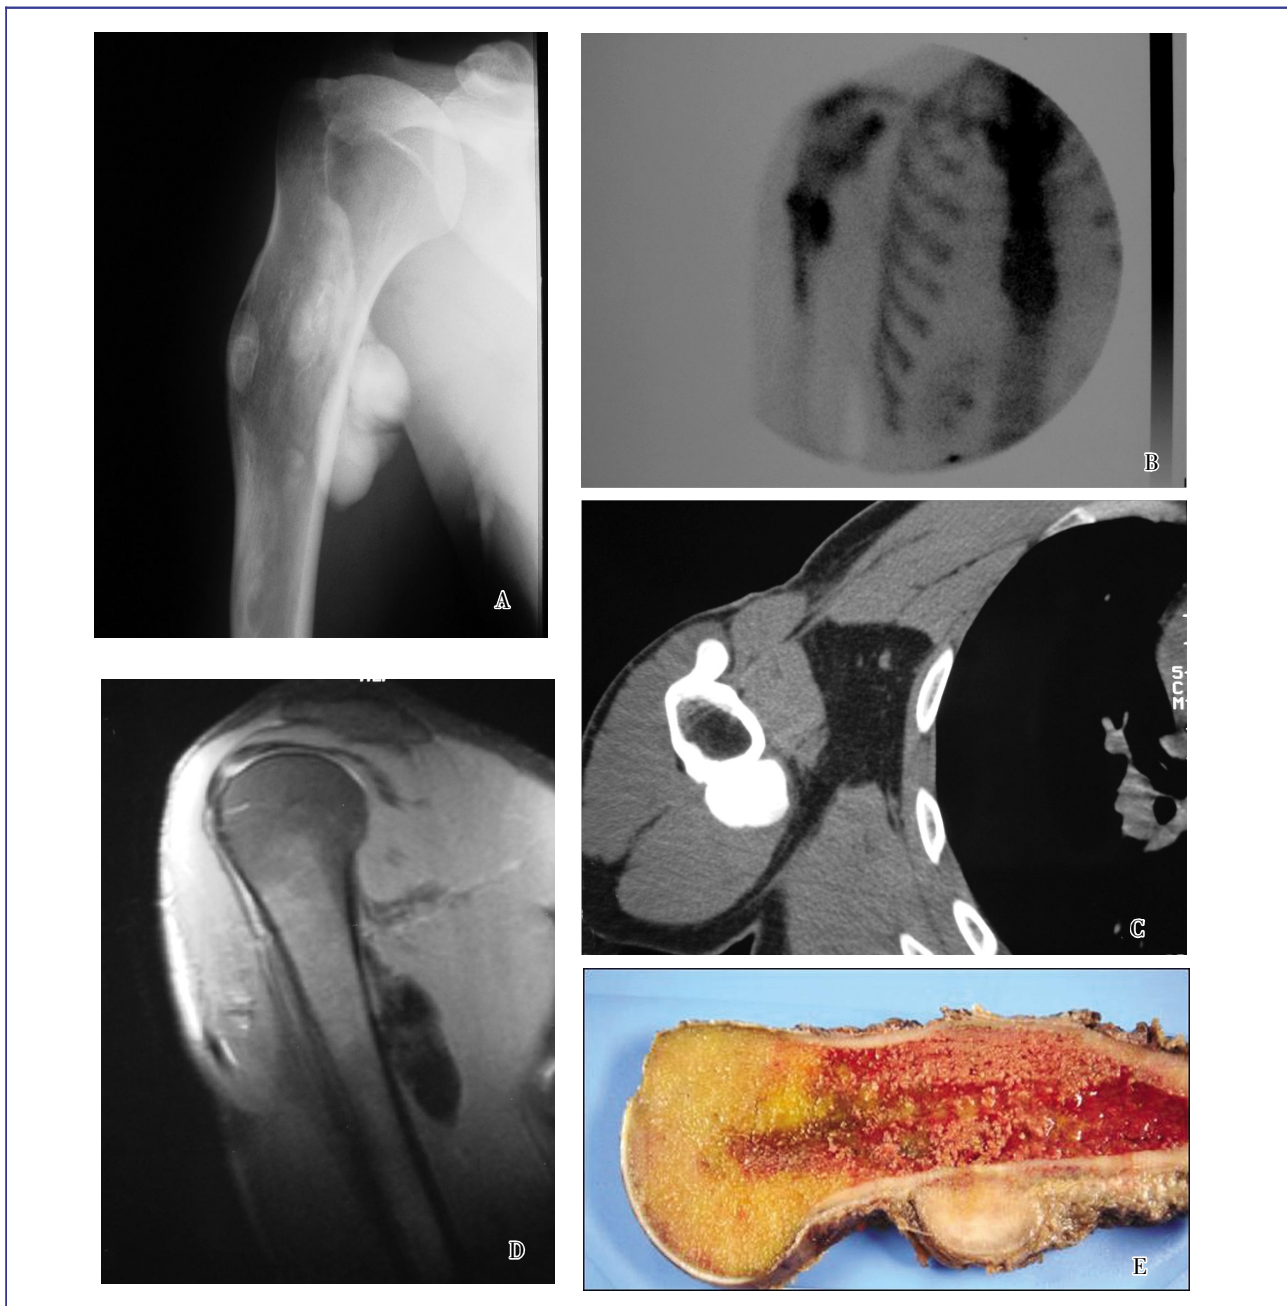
Imaging results of the bone lesion in January 2004. A, anteroposterior view of X-ray image depicts bony deformation and parosteal calcification. B, bone scintigraph shows increased uptake of Tc-99m methyl diphosphonate in the proximal right humerus. Involvement of the posterior cortical portion of the proximal humerus as well as minimal medullary extension are presented. C, axial computed tomography scan shows a large cortical lesion placed in the proximal diaphysis of the humerus with a significant cortical continuity and well-defined borders. The lesion size is 9.0 cm × 2.6 cm × 2.4 cm. No medullary extension is observed. D, magnetic resonance image shows a hypodense mass in the proximal diaphysis of the humerus with an uptake of gadolinium. The posterior cortical involvement and a minimal medullary extension are presented. E, on gross examination, the bone lesion is firm, exophytic and attached by a broad base to the cortex of the humerus.
